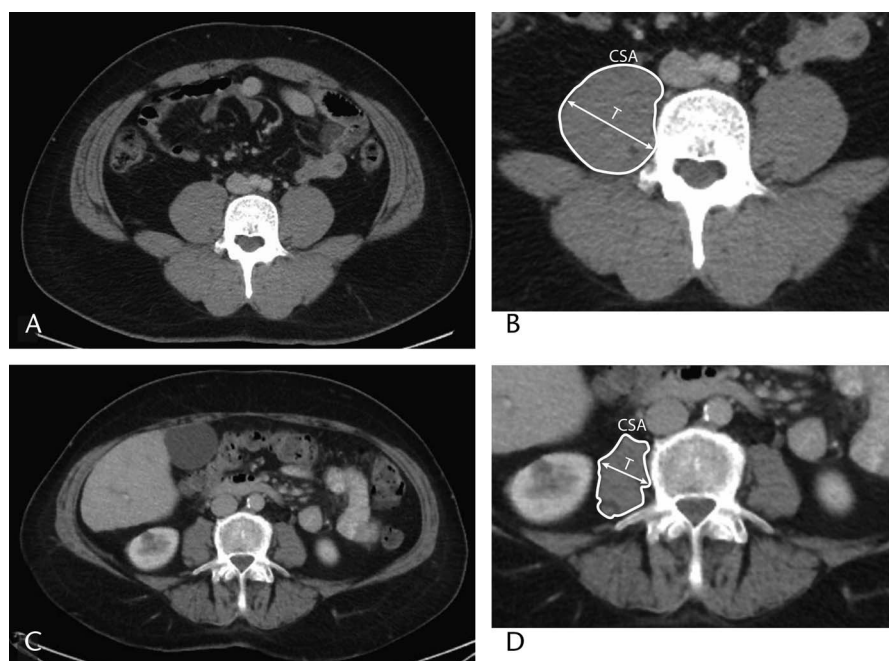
Measurement of psoas muscle thickness and CSA at the fourth lumbar level on a CT image. A and B, Patient with normal muscle mass. C and D, Patient with sarcopenia.
